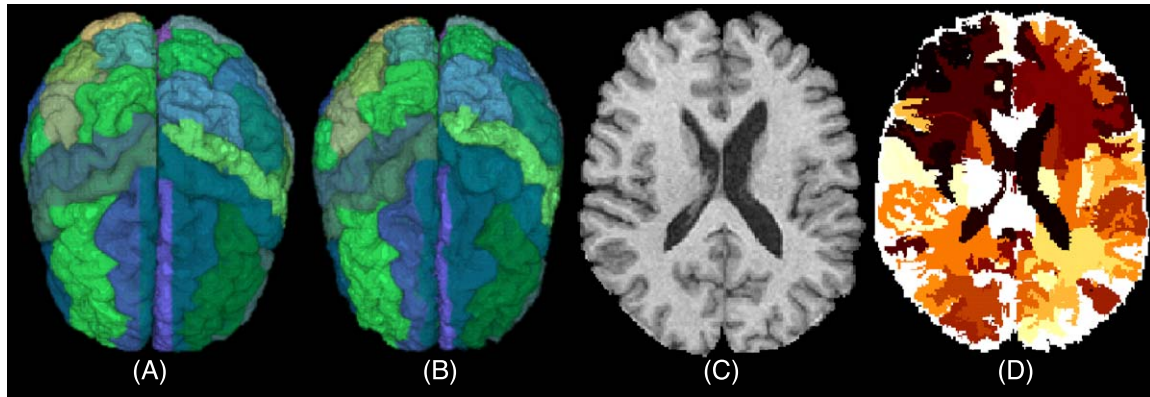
(A) Parcellated brain image used as an atlas for the definition of ROIs. (B) Another individual's image parcellated via a high-dimensional elastic warping of the atlas on the left, using the HAMMER method. (C–D) One cross-section of the individual's original MR image and the corresponding labeled (segmented) image.
